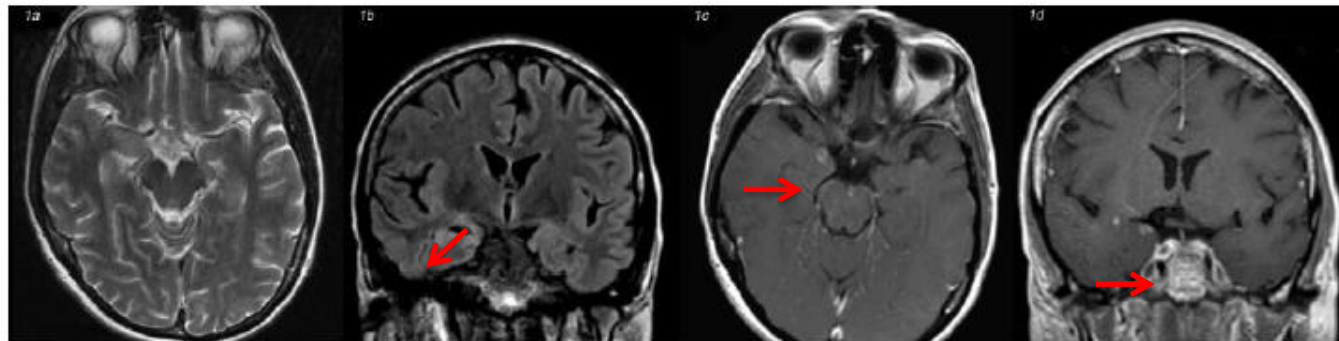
MR images obtained 3 days after presentation. a Transverse T2-weighted image showing right mesial temporal lobe oedema and swelling. b Coronal FLAIR image demonstrating right hippocampal oedema. c, d Transverse and axial contrast-enhanced T1-weighted images showing nodular mesial temporal enhancement.
